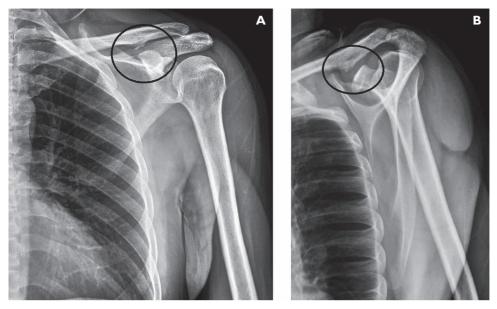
Radiography of the left shoulder in the posteroanterior view (A), and in the lateral scapular view (B), demonstrating arthrosis of the coracoclavicular joint (black circle).
